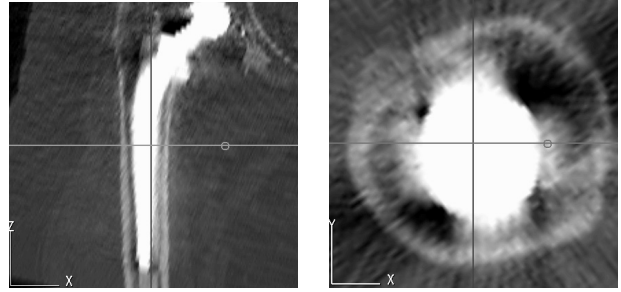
Frontal and cross sectional ORTHODOC views of a CT study of a failing implant.
